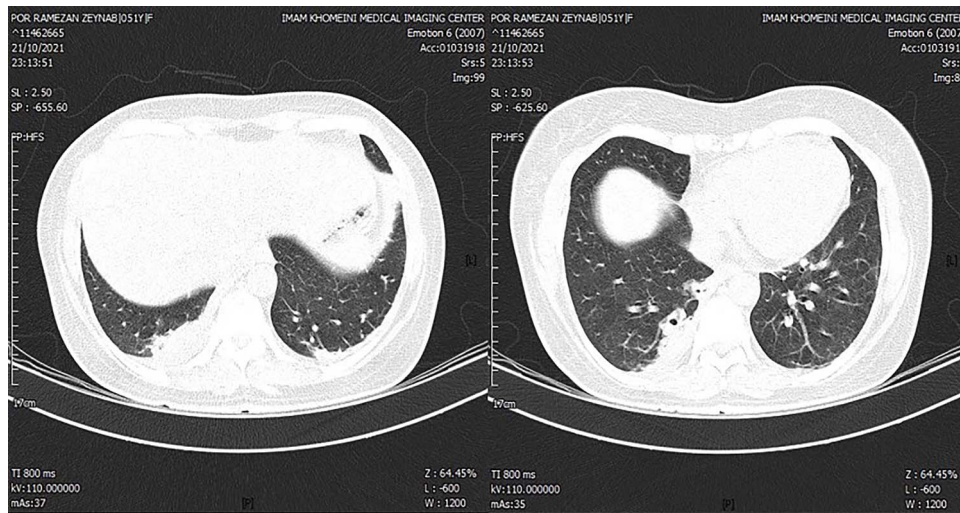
Chest CT scan was done and revealed multilobar ground glass opacification, which was in favor of COVID-19.
